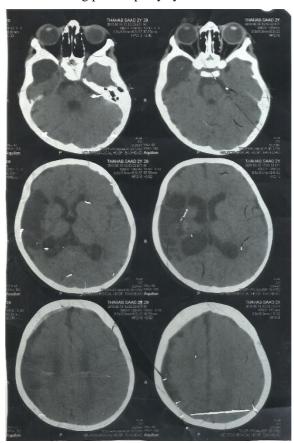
Brain CT scan showed large right sided temporoparietal gliotic changes with large communicating porencephaly cyst.
